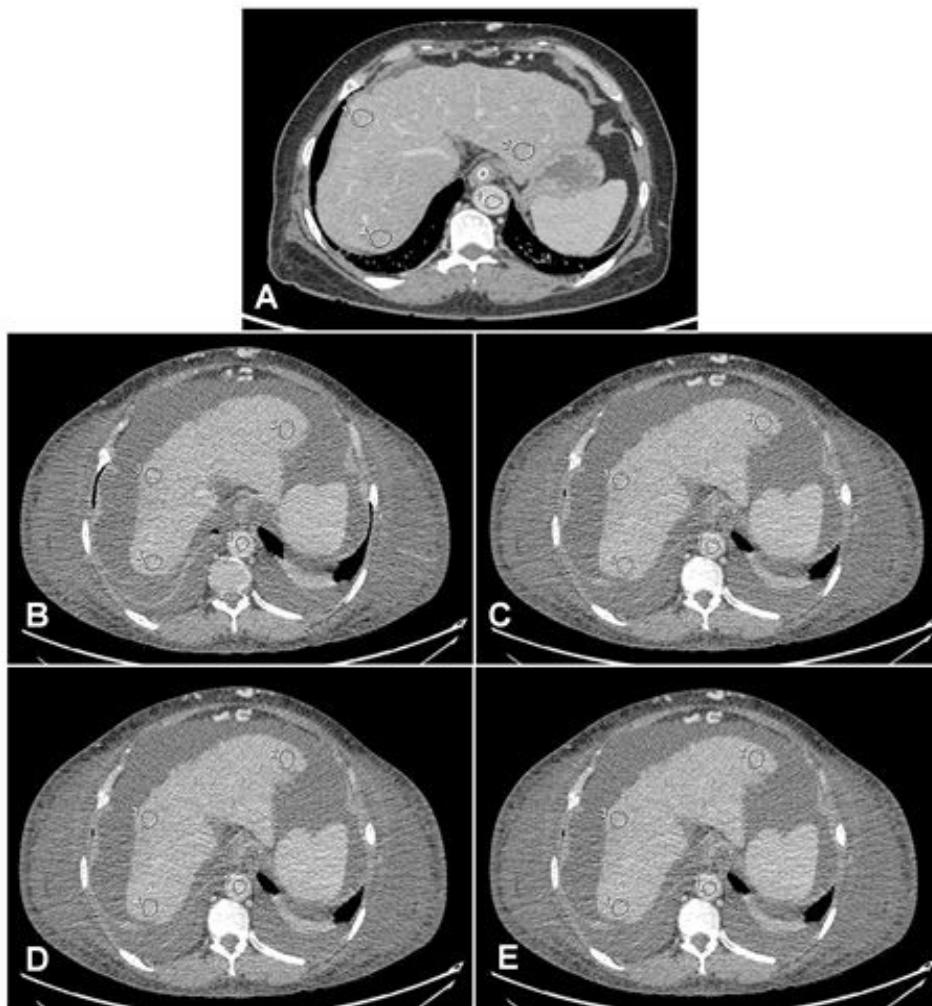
Poor image quality on low dose abdominal CT due to ascites and subcutaneous edema. Axial portovenous abdominal CT of a 58-year-old female with cirrhosis and portal hypertension (A-E)
